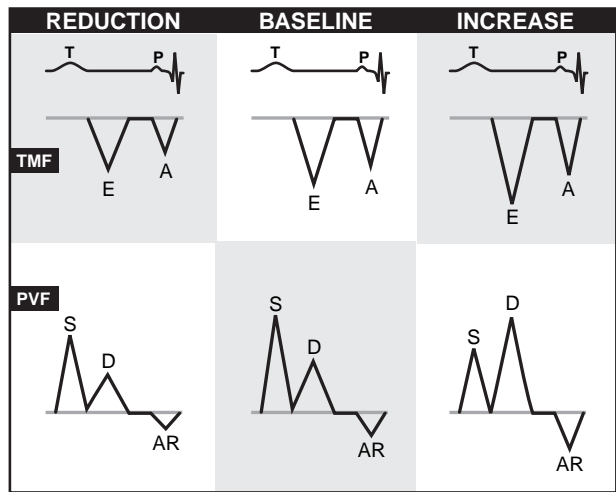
Effect of changes in preload on the pulsed-wave Doppler interrogation of the transmittal valve flow (TMF) and the pulmonary venous flow (PVF). With reduction in volume, both the early diastolic mitral valve inflow E-wave and the diastolic D-wave of the PVF are reduced. With increase in preload, the TMF E-wave and PVF D-wave are increased (AR, atrial reversal).
